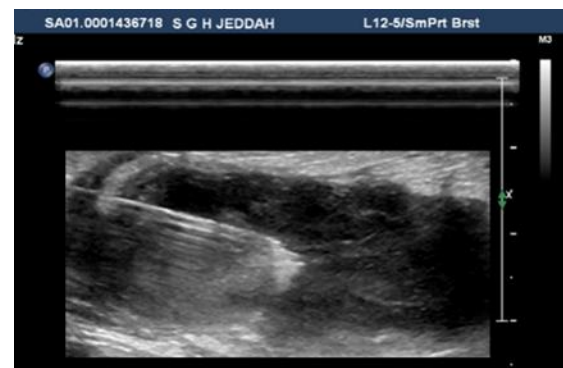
Ultrasound guided drainage of a breast abscess with the needle in place
